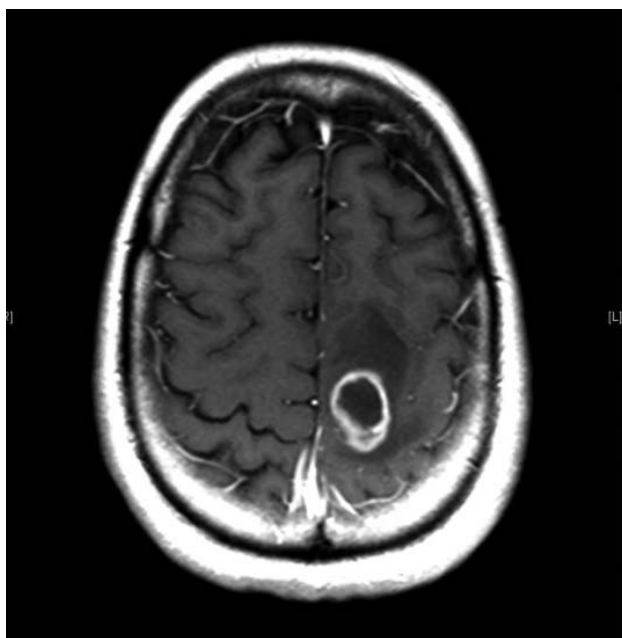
Initial imaging. Axial T1-weighted postgadolinium MRI showed a ring-enhancing, centrally necrotic mass in the left posterior frontal lobe with surrounding vasogenic edema.
